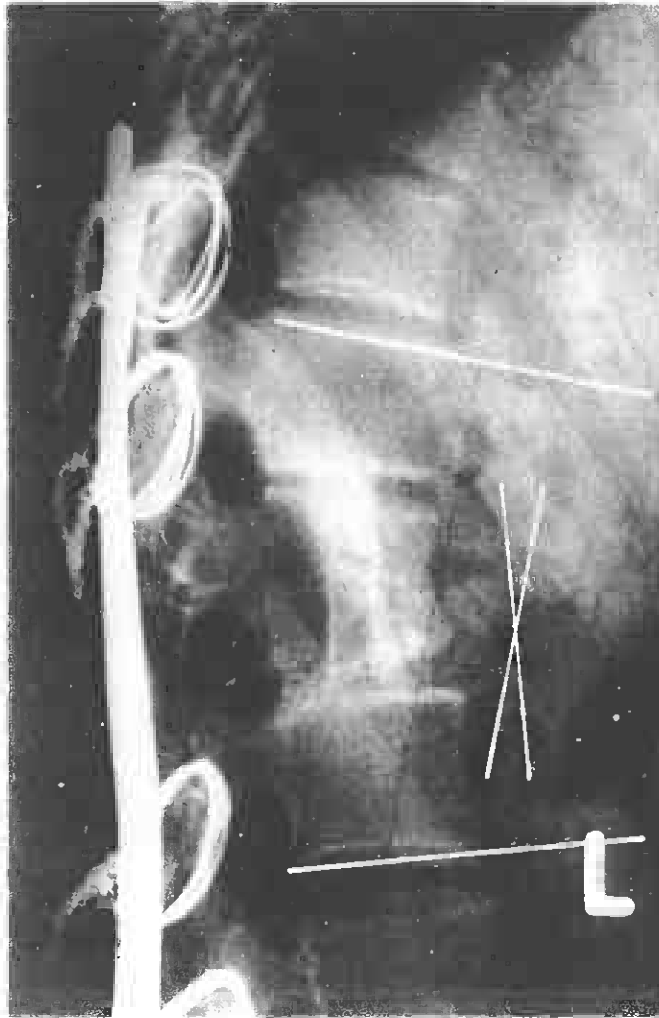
(d) 27-month follow-up radiograph of P.P.
